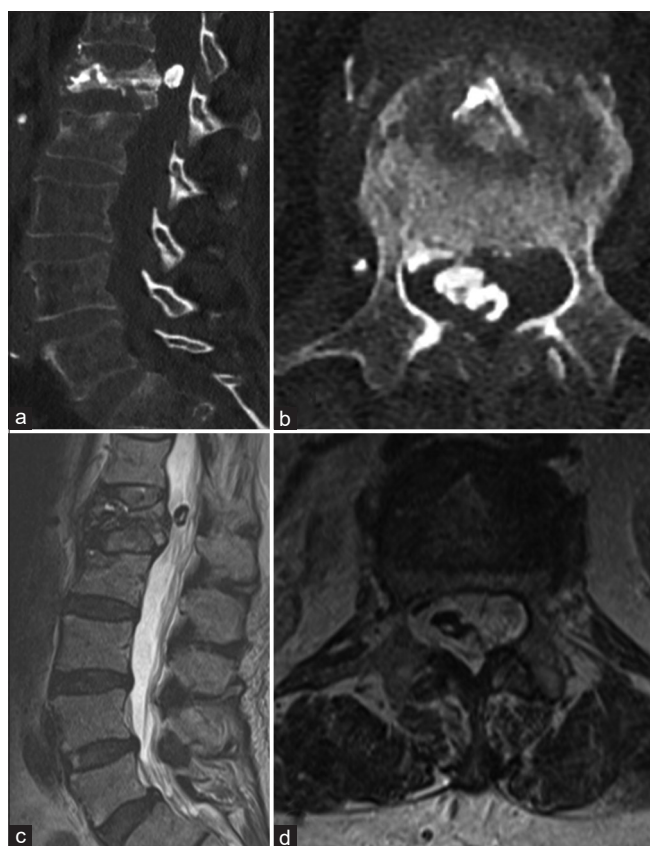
Computed tomography (a and b) and magnetic resonance imaging (c and d) of the patient's lumbar spine demonstrated cement leakage into the spinal canal at the L1 corpus level.
